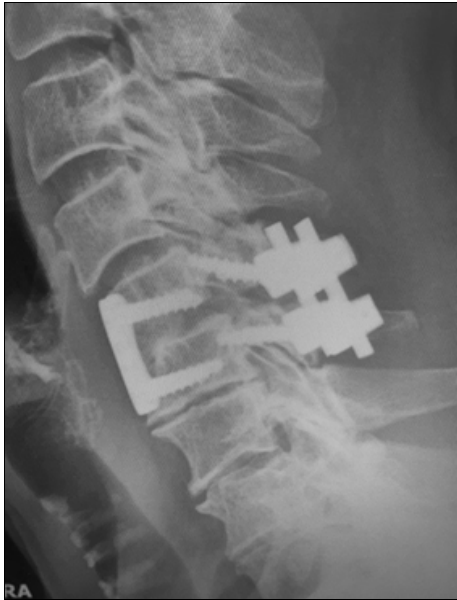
Final follow up x-ray
